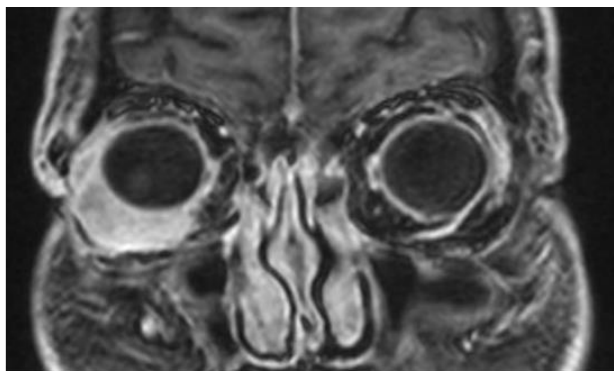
Patient X., 72 years old, magnetic resonance imaging fragment.
